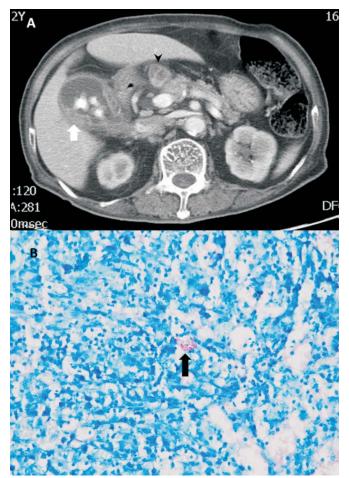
(A) Computed tomography of abdomen disclosed a heterogeneous enhanced mass (white arrows), and paraortic lymph node (arrowhead), (B), positive acid-fast bacilli (black arrows).
